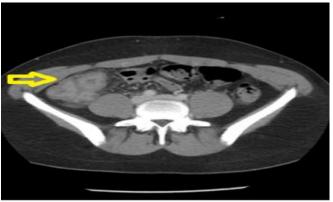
Axial CT scan in a patient with Crohn's disease. Yellow arrow indicates thickening of the terminal ileum (*comb sign*) in Crohn's disease (Gajendran et al., 2018).
